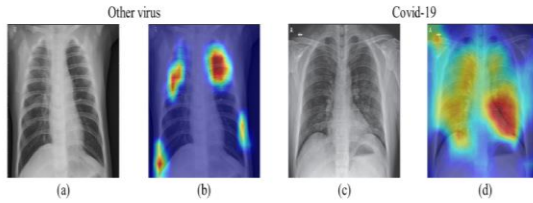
Diagnostic result in chest x-ray dataset, the original image is (a) (c), (d) result is positive (infected with COVID-19), (b) result is negative (infected with another virus)[11]
